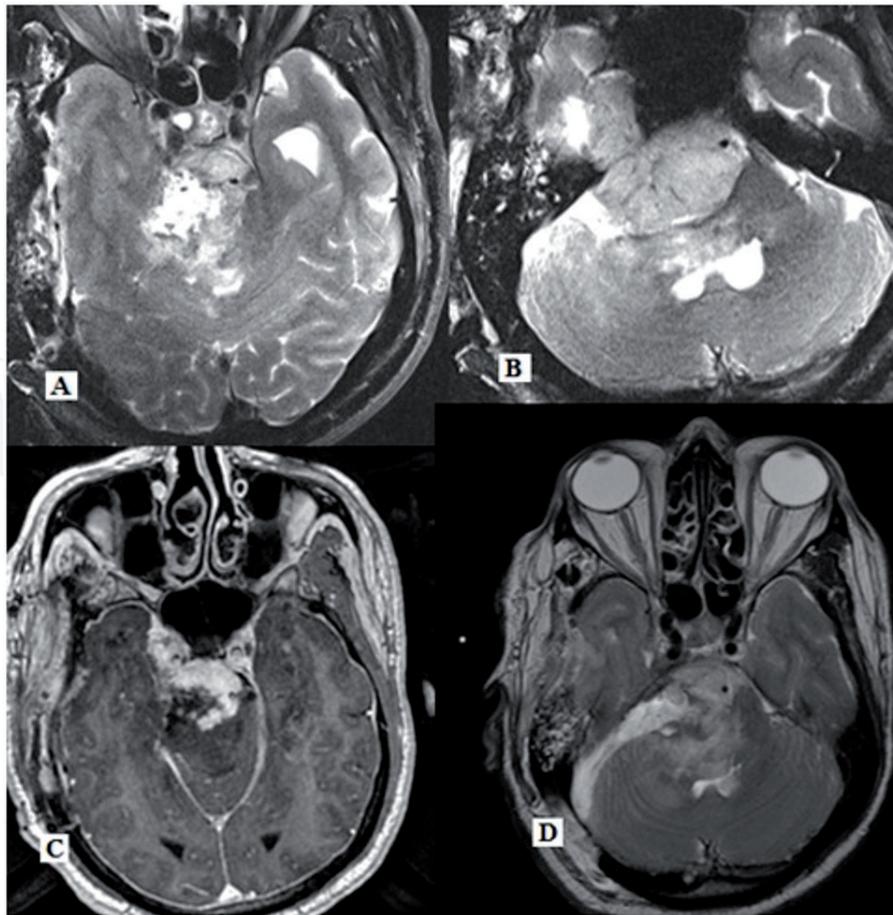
A&B ioMRI images of sphenopetroclival meningioma, initially tumor was decompressed by subtemporal approach but due to intra operative bleeding and hard calcified which was unable to mobilize. In this case ioMRI helped surgeon to approach by retromastoid craniotomy and achieve further resection of tumor as safely as possible in the same sitting. C&D. post-operative MRI images showing residual tumor. Volume of the residue is significantly reduced compared to that of in ioMRI.*
